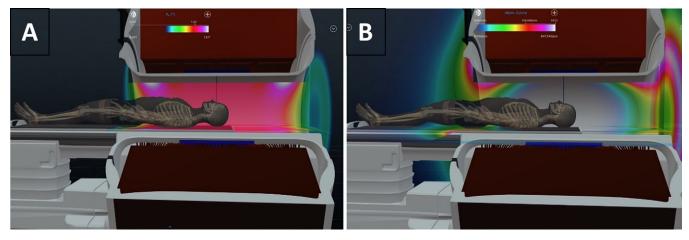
Three-dimensional depiction of (A) the static B₀ magnetic field and (B) spatial field gradient in a 1.5-T MRI scanner for unloaded MRI scanners or coils. The near side of the scanner has been rendered transparent so that the energies/fields can be depicted three-dimensionally throughout the MRI scanner bore and room. The strength and spatial distribution of the static magnetic field B₀ and spatial field gradient are depicted. Notice that, in the homogeneous static magnetic field at the center of the MRI scanner, the strength of the spatial field gradient and, therefore, potential translational forces on ferromagnetic materials and objects are minimal. The greatest translational forces scale with the spatial field gradient of this magnet, which maximizes near the radial extremes or borders at the entrance (and exits) to the MRI scanner bore. Images courtesy of Emanuel Kanal, MD, Presbyterian University Hospital, University of Pittsburgh Medical Center, created using MagnetVision (Advanced Magnetic Analytics).
